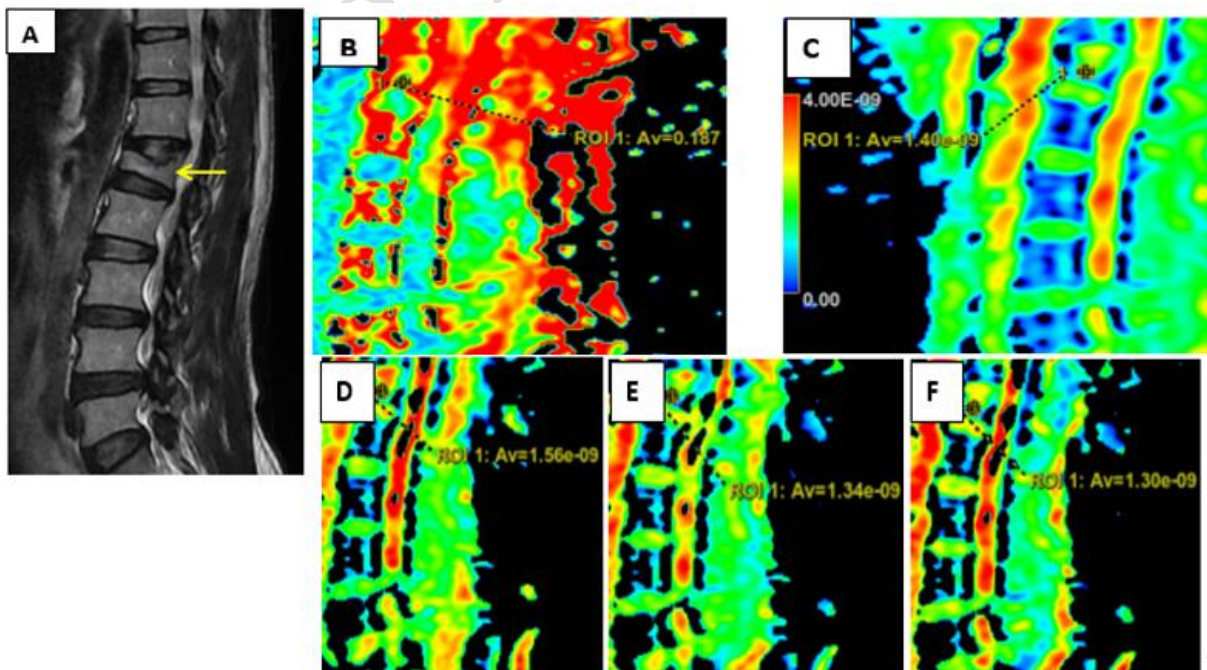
(A-F images): A 50-year-old male patient, he has a history of trauma. (A) Sagittal T2-weighted MR image acquired at 1.5 T shows decreased height of L1 vertebral body (yellow arrow), (B) Sagittal color coded FA map image shows decreased FA value at the level of vertebral fracture (0.187), (C) Sagittal color coded ADC map image shows increased ADC value at the level of vertebral fracture (1.40), and (D, E& F) Sagittal color coded diffusion coefficient images at (X,Y,Z) with increased MD (1.40) Findings consistent with benign traumatic vertebral collapse.
